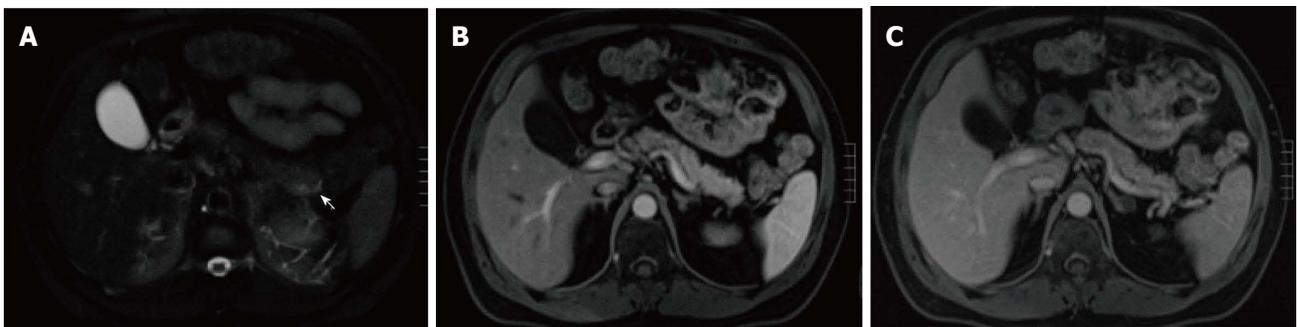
Subtle focal acute edematous pancreatic tail pancreatitis. A: Axial T2 weighted-image with fat-suppression; B and C: Axial post-contrast 3D-GRE T1-weighted images with fat-suppression during the late arterial and portal venous phases. There is a very subtle area of increased T2 signal seen around the pancreatic tail (arrow, A), with fairly normal enhancement of the pancreas on the post-contrast images (B and C) in keeping with subtle focal acute edematous pancreatic tail pancreatitis.
